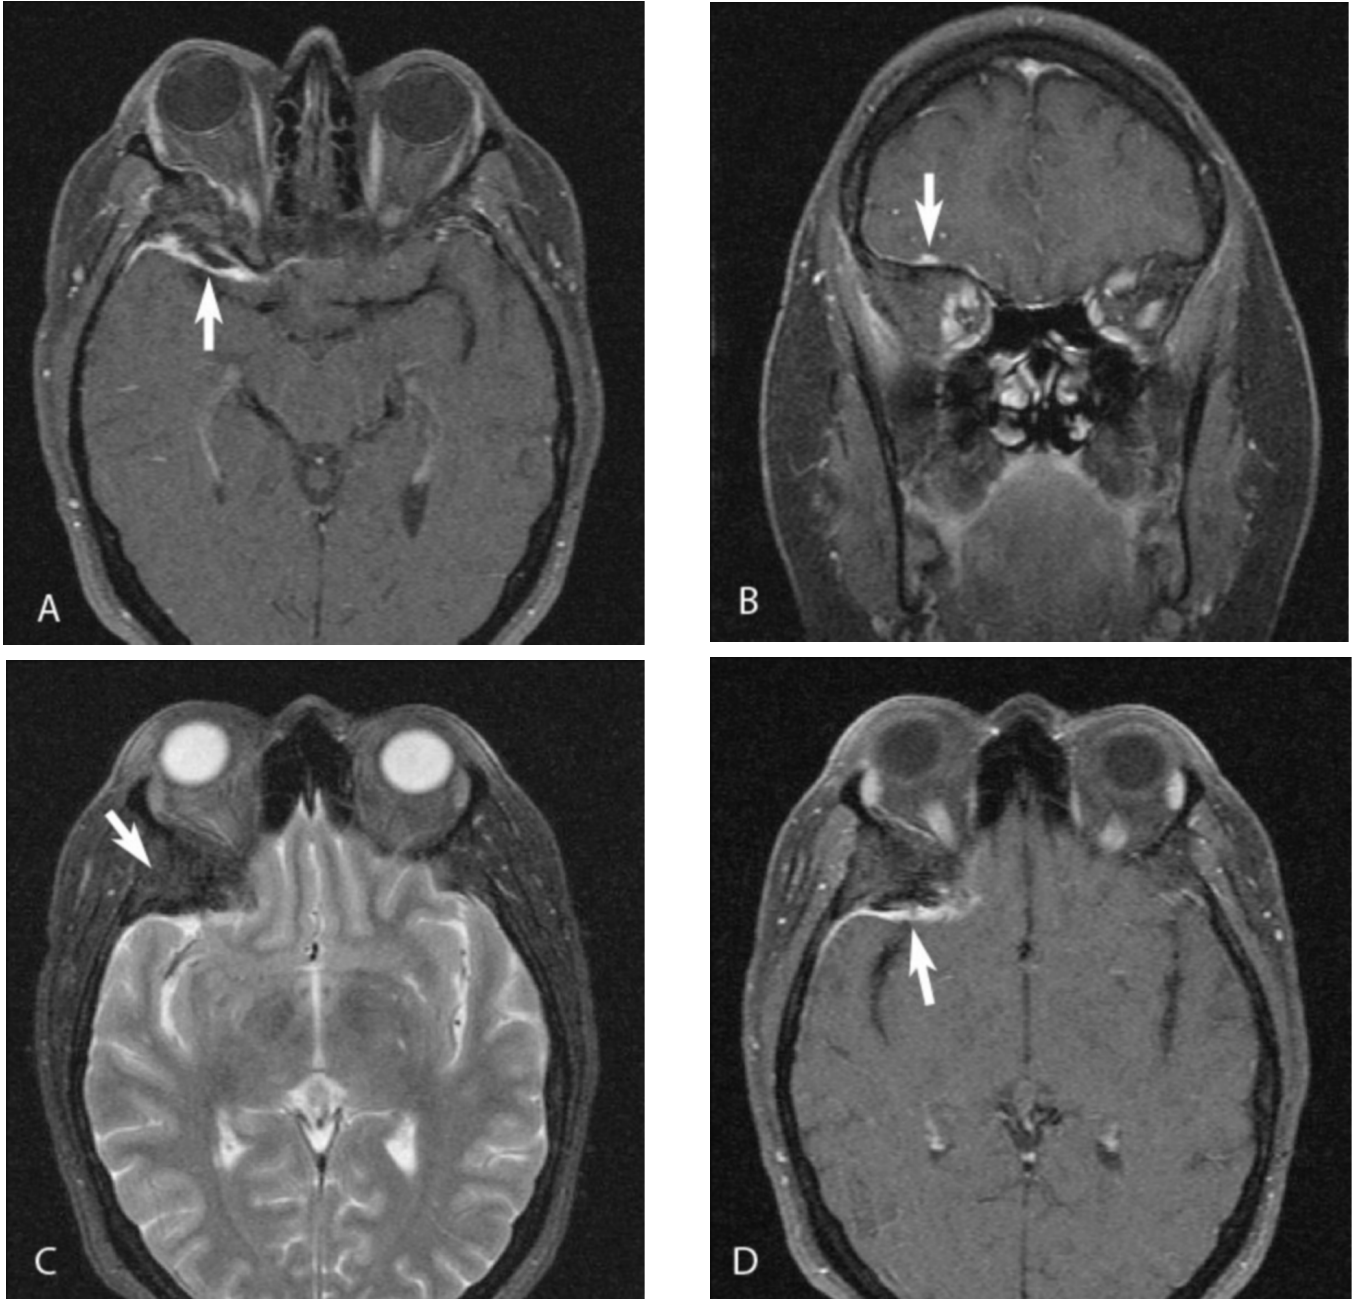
50-year-old female with intraosseous meningioma. A (axial), B (coronal), and C (axial) T1-weighted fat saturation postgadolinium with fat saturation; D, axial T2-weighted image. These images demonstrate calvarial thickening involving right sphenoid wing and lateral orbital wall (arrows), with adjacent dural enhancement overlying anterior temporal lobe encroaching on the planum sphenoidale. There is a mass effect on the right lateral rectus muscle.
